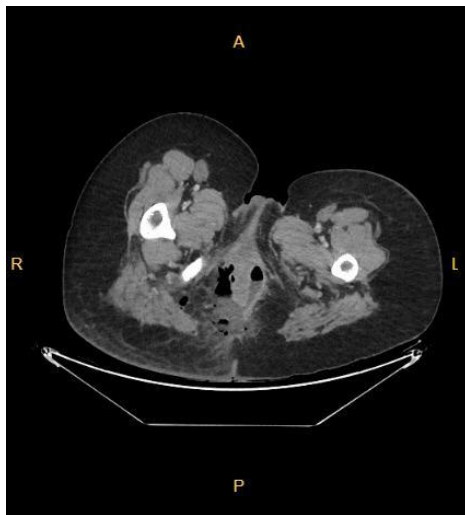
CT scan image showing gas bubbles in the perianal soft tissue
